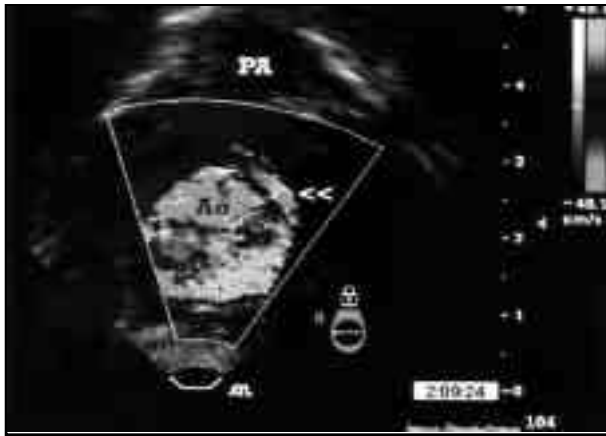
(A) In comparison to the case in Fig. 3, severe stenosis of the interarterial, intramural segment of the left main coronary artery before its bifurcation in a patient who presented in cardiac arrest. The transesophageal Doppler color flow pattern showing color aliasing at the stenotic intramural segment.
